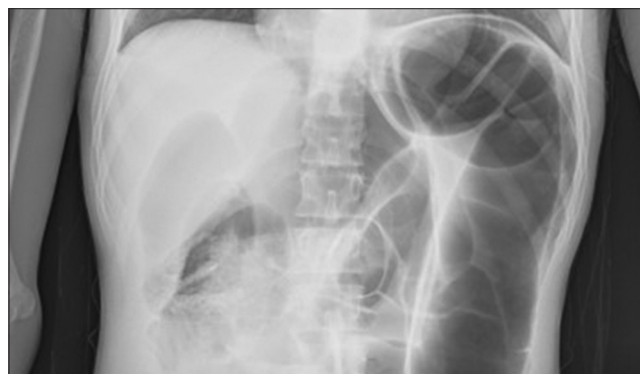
Abdominal X-ray showed dilated large intestine-ileus
